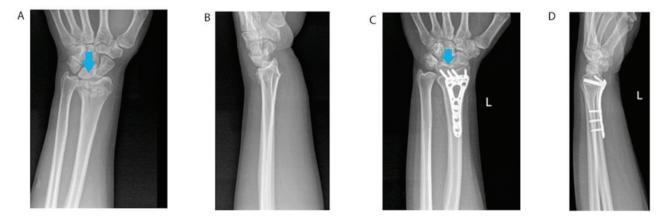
Successful surgical treatment of a type III fracture. (A) Anteroposterior and (B) lateral radiographs of the fracture prior to treatment. (C) Anteroposterior and (D) lateral radiographs of the fracture after the treatment. The arrow indicates the fracture site.
